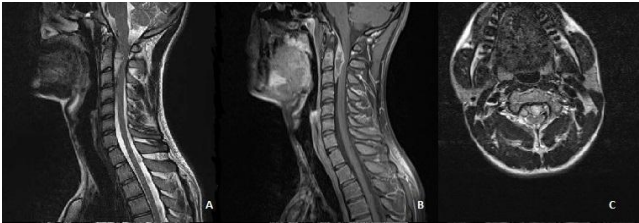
The cervical MRI findings sagittal T2 weighted (A), T1 weighted sagittal (B) and axial (C) images with contrast enhancement showing extradural, cranio-caudal lesion concomitant with meningioma at C2-C3 levels of the cervical spinal cord
